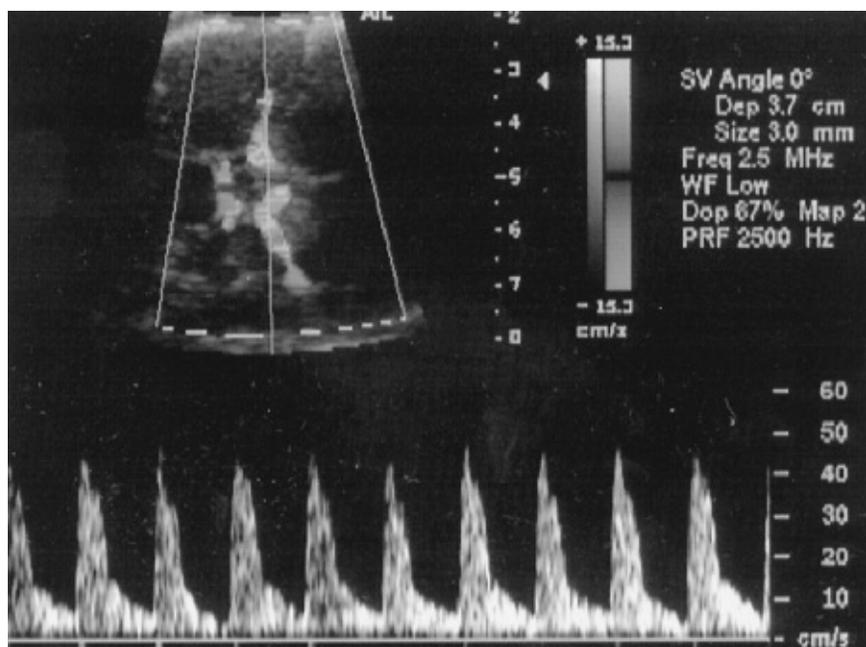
The ultrasound color Doppler image shows the circle of Willis and the MCA branches. Also shown is the near 0-degree angle of insonation and a normal MCA FVW.
